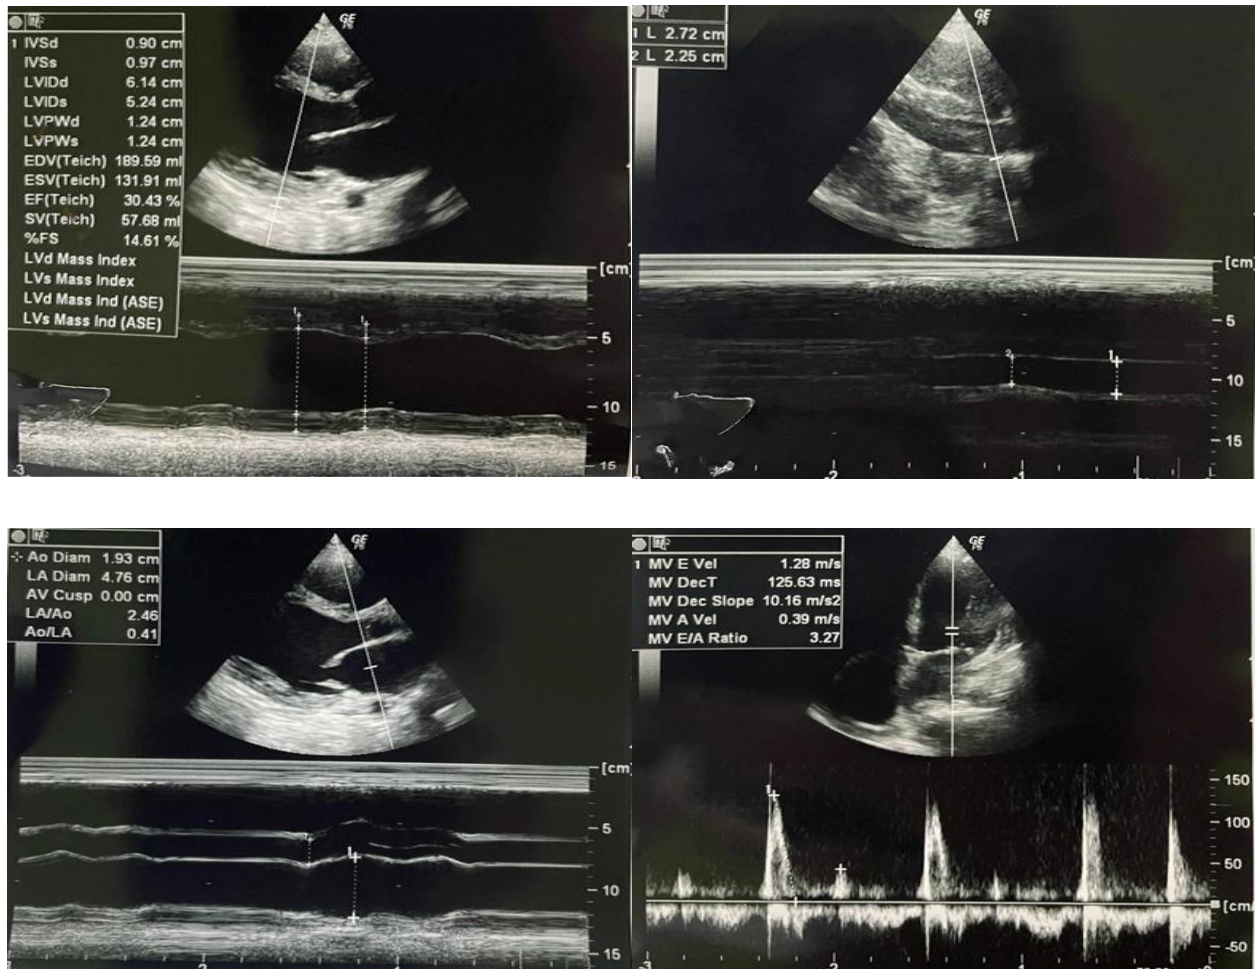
Echocardiography shows dilatation of all cardiac chambers, eccentric LVH, severely reduced left ventricular systolic function with an EF of 30%, grade III diastolic dysfunction, normal right ventricular contractility, global hypokinesia, and mild mitral regurgitation
